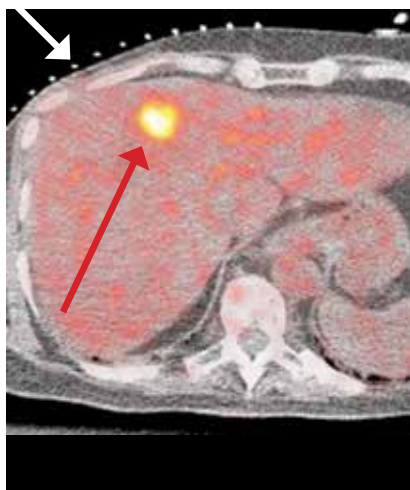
Planning PET/CT performed with 30-second breath hold by suspending ventilation during the general anesthesia. Fused PET/CT image shows hypermetabolic solitary liver metastases (red arrow) corresponding to the hyperintense lesion seen on MRI. The opaque skin markers (white arrow) represent a grid attached to the patient's skin over the liver for determining the coordinates for insertion of the ablation probe.
